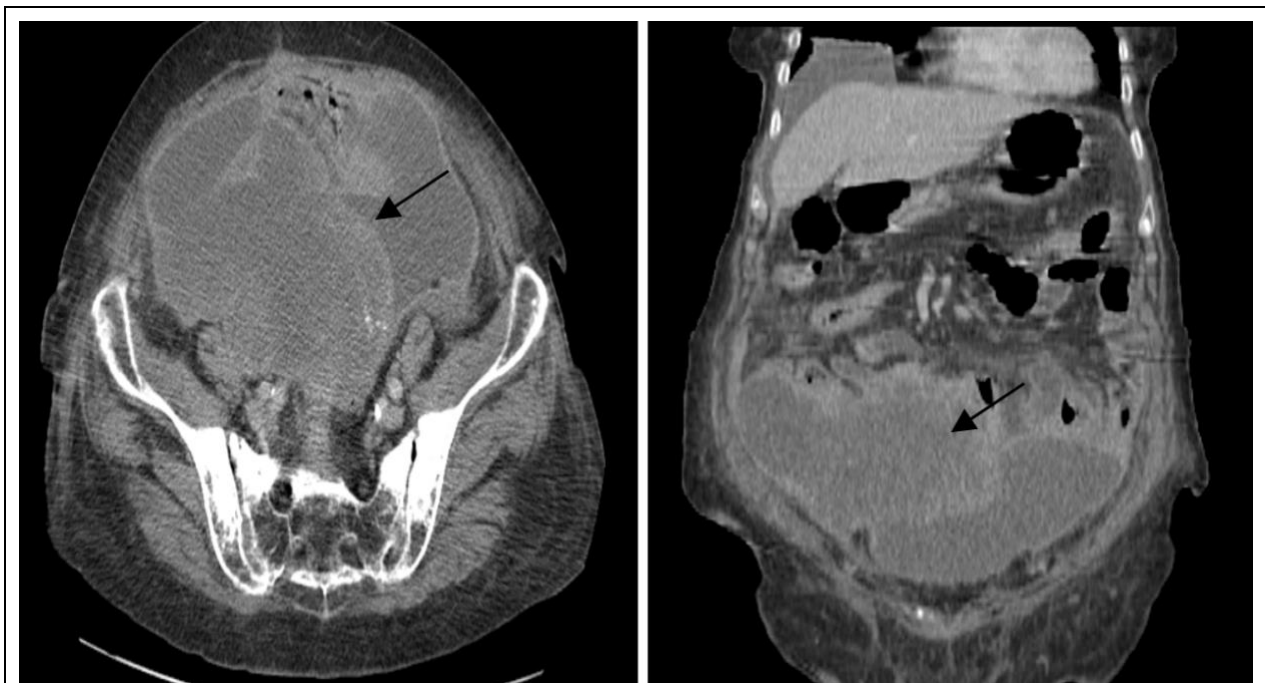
Abdominopelvic contrast-enhanced CT scan: Abdominopelvic lesions with liquid content, containing a few air bubbles, confluent, with enhanced walls, associated with peritoneal fat infiltration, and moderate pelvic and perihepatic peritoneal effusion, measuring 129 x 40 x 82cm (transverse x height x anteroposterior).
